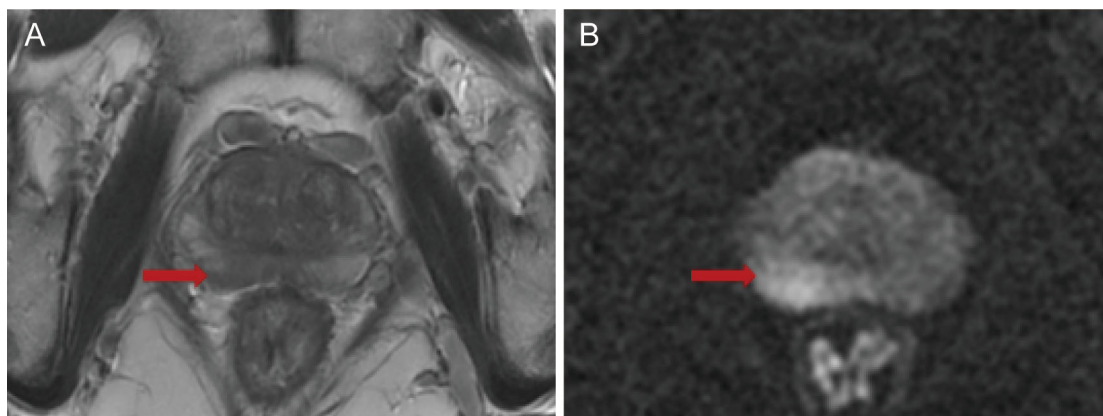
(A) T2-weighted imaging (T2WI); (B) diffusion-weighted imaging (DWI).
